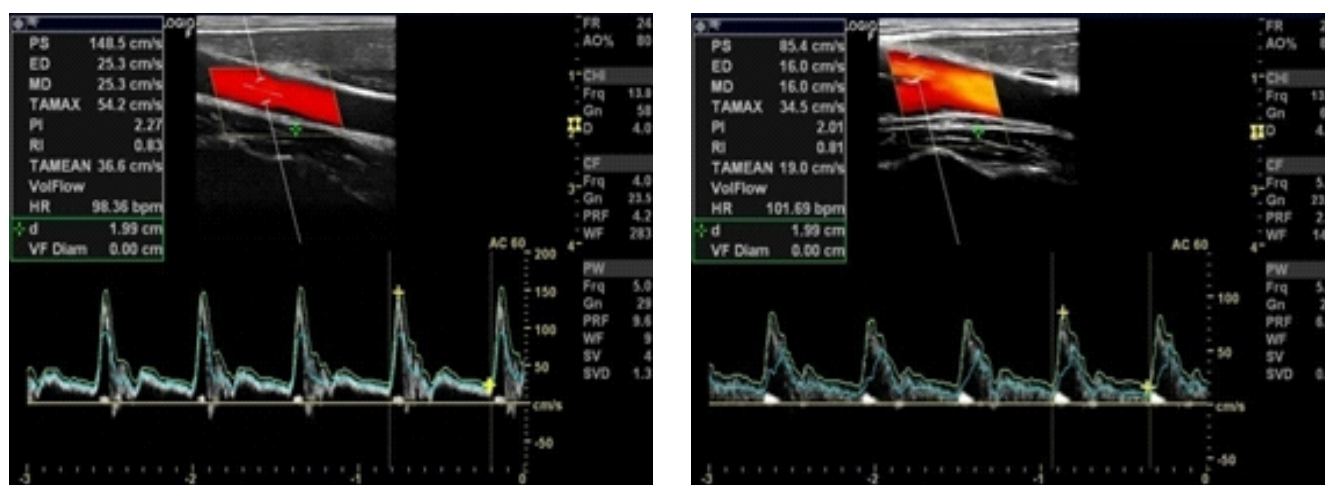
Typical normal Doppler spectral obtained from the right CCA (left) and right ICA (right)
